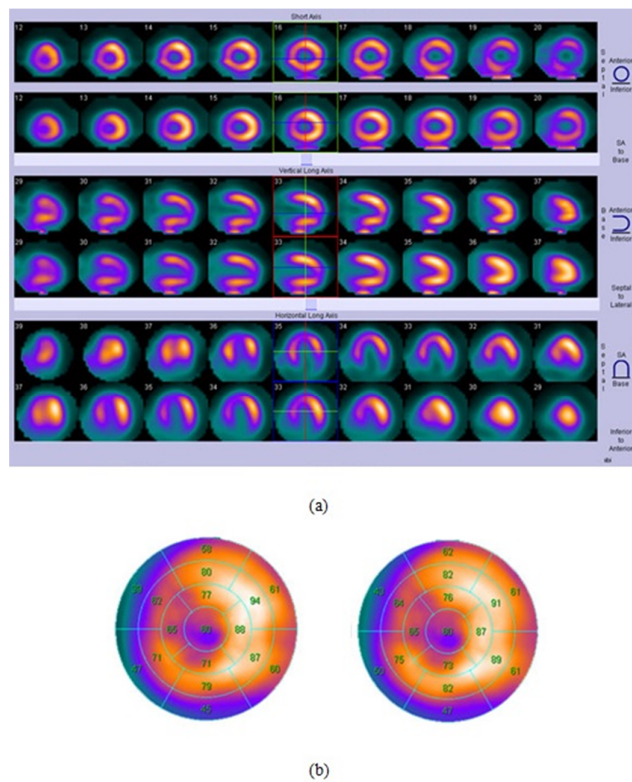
(a): short axis, vertical and horizontal long axis of SPECT image of a typical patient with ICD lead corrected for attenuation without MAR (top row) and with MAR (bottom row) (b): Bull's eye view of SPECT images corrected for attenuation without MAR (left) and with MAR (right).
